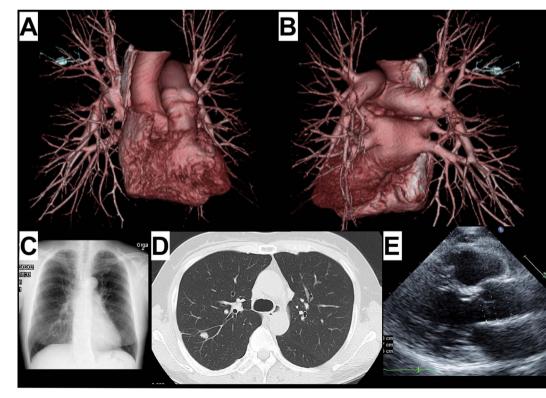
(A and B) Three dimensional reconstraction image of contrast-enhanced CT angiography. Anterior (A). Posterior (B). (C) A chest X-ray at admission. (D) Coin lesion in CT scans. (E) Echocardiography.
